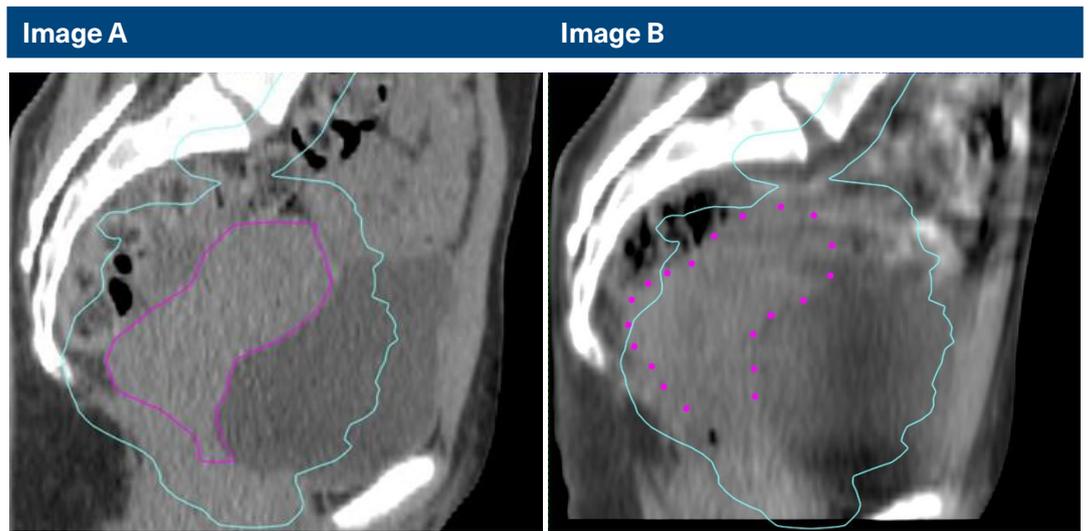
fraction 1 CBCT. The PTV is outlined in blue, the CTV in red. Note uterus distention causing poor CTV coverage.
